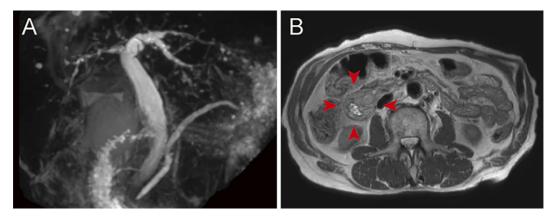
Magnetic resonance imaging on admission. Magnetic resonance cholangiopancreatography demonstrated the absence of a defect in the diffusely dilated common bile duct (A). Duodenal wall thickening was noted on T2-weighted imaging (B) (arrowheads).
